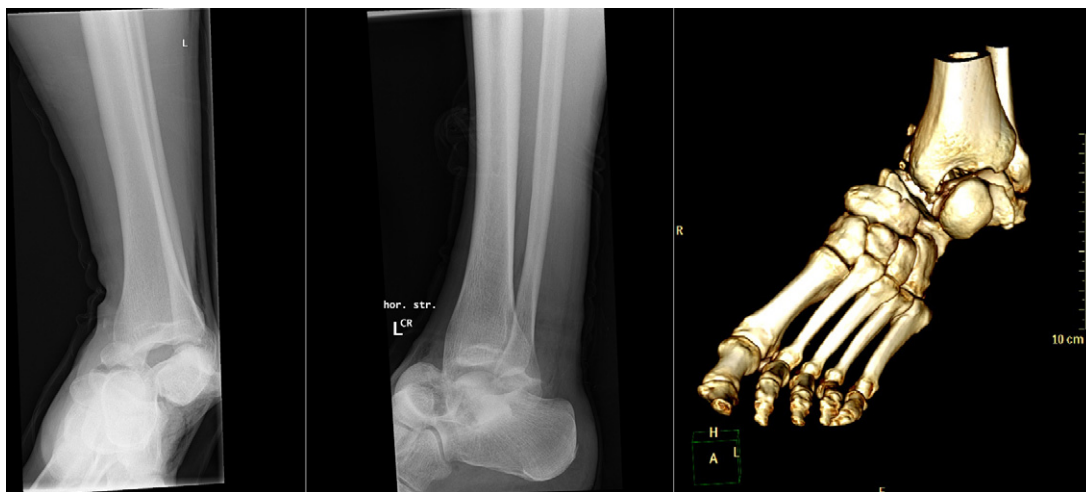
X-ray of a left ankle with 3D CT reconstructions: complete dislocation of the tibiocalcaneal joint and subtotal dislocation of the tibiotalar joint combined with comminuted talar fracture.
